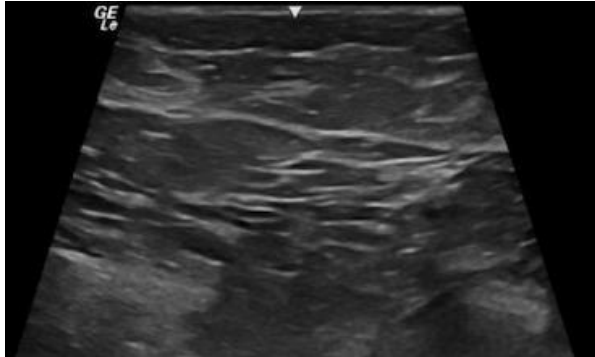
Sonographic cross-sectional view of benign breast tissue with typical hyperechoic.
